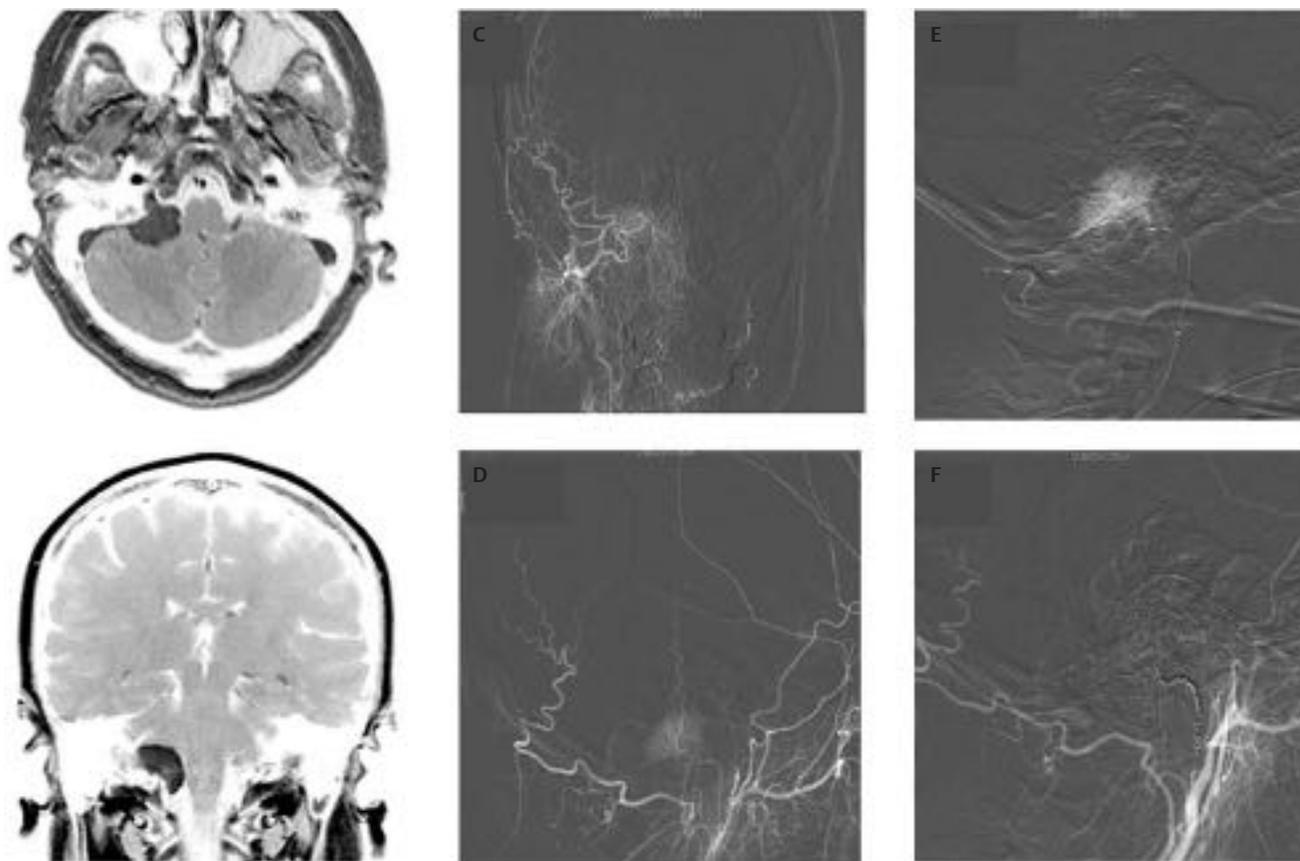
Right ventral cerebellar meningioma. (A) Axial and (B) coronal magnetic resonance imaging. (C) Anteroposterior and (D) lateral superselective angiograms of the left external carotid artery demonstrating a tumor blush supplied by neuromeningeal branches of the ascending pharyngeal artery. (E) Superselective angiogram of the ascending pharyngeal artery in the lateral projection demonstrates robust vascular supply through the neuromeningeal trunk. (F) Lateral external carotid artery angiogram following coil embolization demonstrates a significant decrease in the size and intensity of the tumor mass. Platinum coils were chosen in this case due to safety resulting from proximal placement. Embolization with polyvinyl alcohol or liquid embolic agent may risk ischemia to the cranial nerves exiting through the jugular and hypoglossal foramina.
